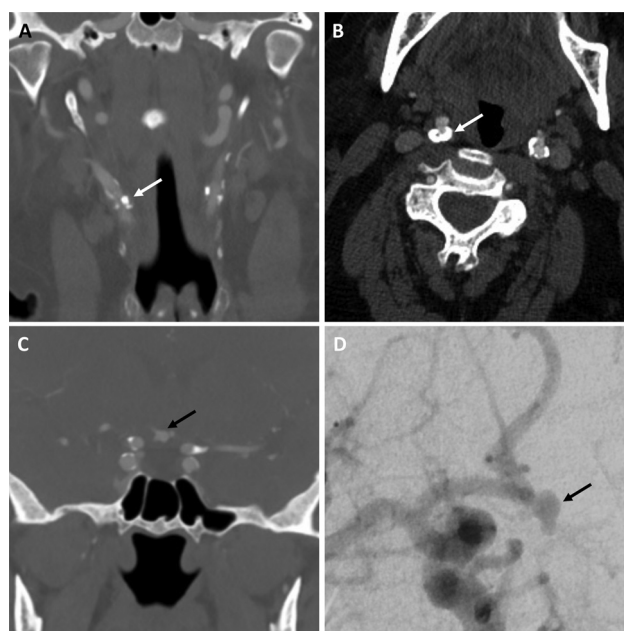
Preoperative imaging. A 69-year-old woman was found to have a high-grade right ICA stenosis and an ipsilateral unruptured intracranial aneurysm on workup for headache, dizziness, and diplopia. Coronal (A) and axial (B) CTA demonstrated a calcified atherosclerotic plaque resulting in 90% stenosis of the right ICA (white arrows). Coronal CTA (C) and right ICA injection oblique view on digital cerebral angiography (D) showing a wide-necked (2.9-mm neck, 4.8-mm dome) anterior–inferior projecting aneurysm with multiple secondary excrescences arising from the right A1–2 region (black arrows). CTA, computed tomography angiography; ICA, internal carotid artery.
